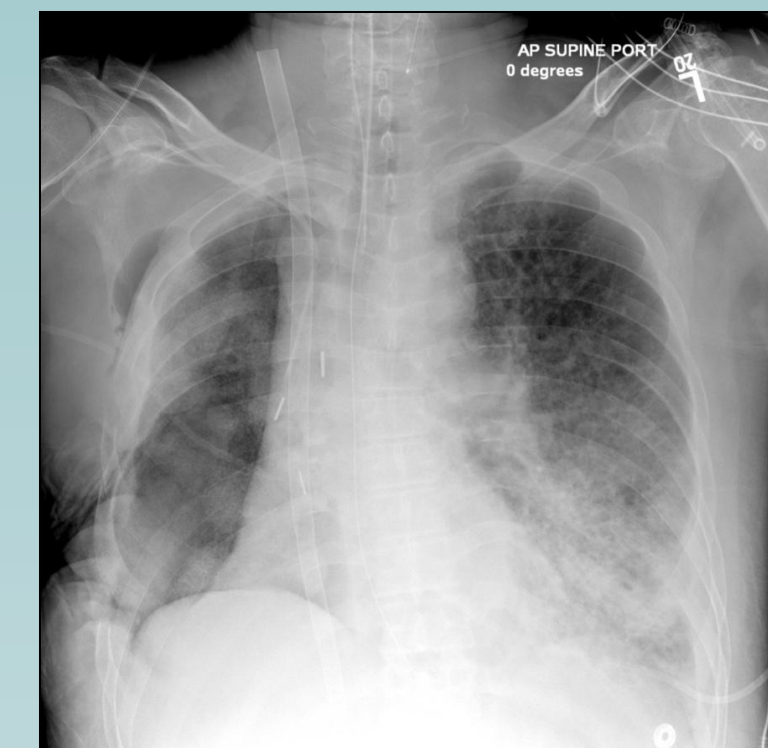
X-Ray of a patient with ARDS and the dual-lumen catheter inserted
